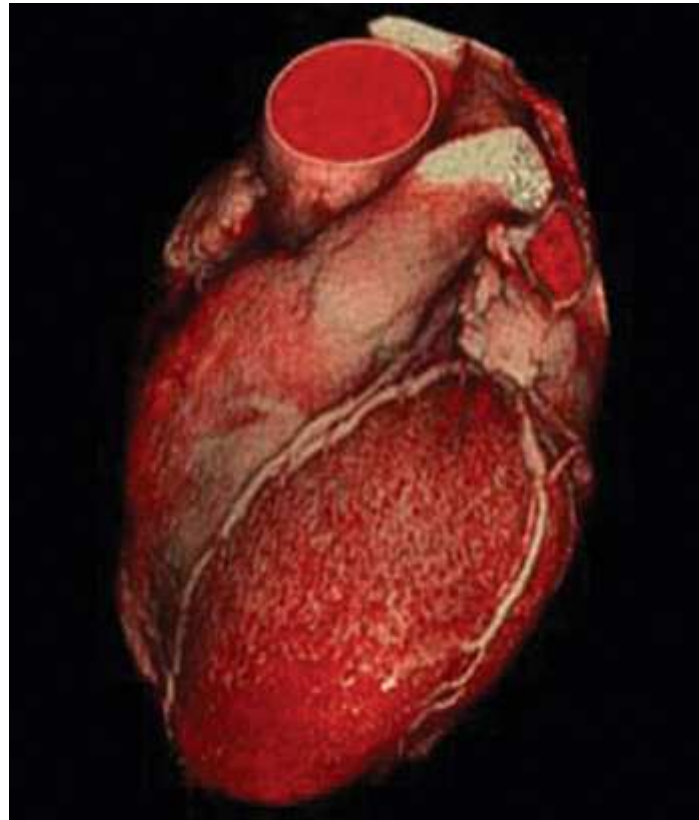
Color three-dimensional cardiac CTA.
